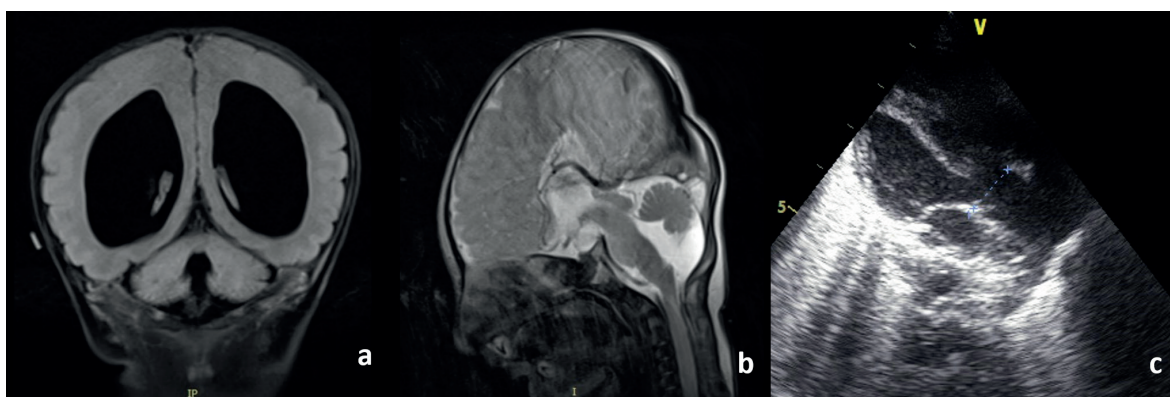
(a) Magnetic resonance imaging revealed inferior vermian hypoplasia and ventriculomegaly. (b) Agenesis of corpus callosum. (c) Echocardiography displayed presence of double outlet right ventricle.
